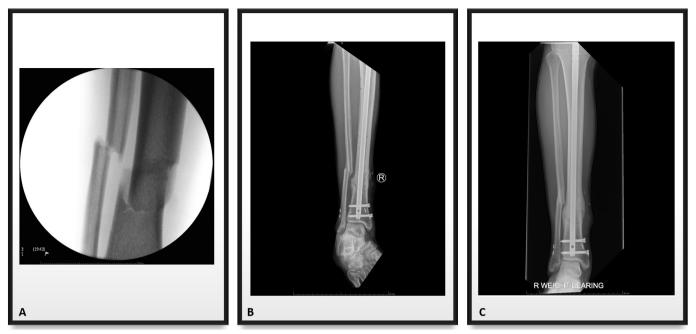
Radiology: (A) Intra-operative image of a tibia-fibula fracture following a poorly timed kick in an English premier League match. (B) X-ray image of remodelling tibia-fibula fracture (15-week post-injury). (C) X-ray image of full union following tibia-fibula fracture (28-weeks post-injury).
